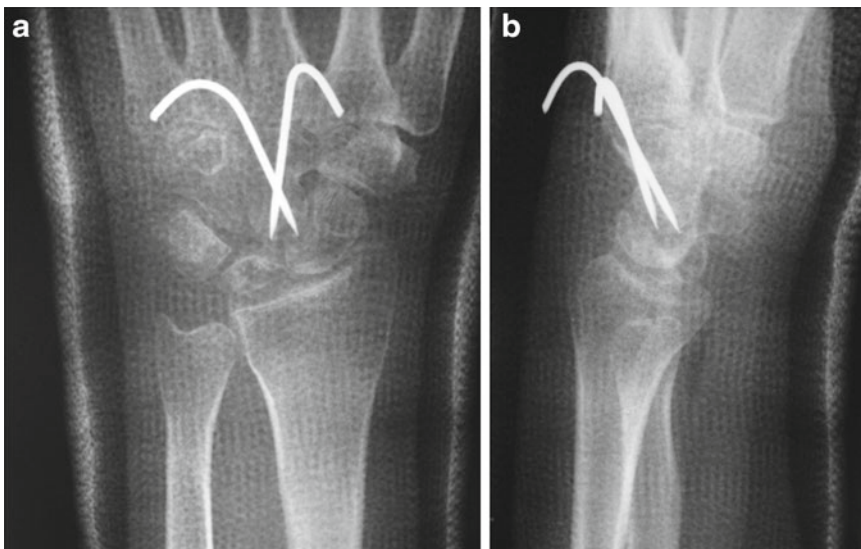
Anteroposterior radiographs of the left wrist 7 weeks postsurgery. (a) Anteroposterior view. (b) Lateral view
